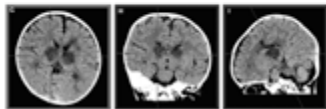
Clinical Example: Acute necrotizing encephalopathy of childhood. T2-weighted images show bilateral, symmetric, hyperintense lesions in the white matter, suggesting demyelination.
